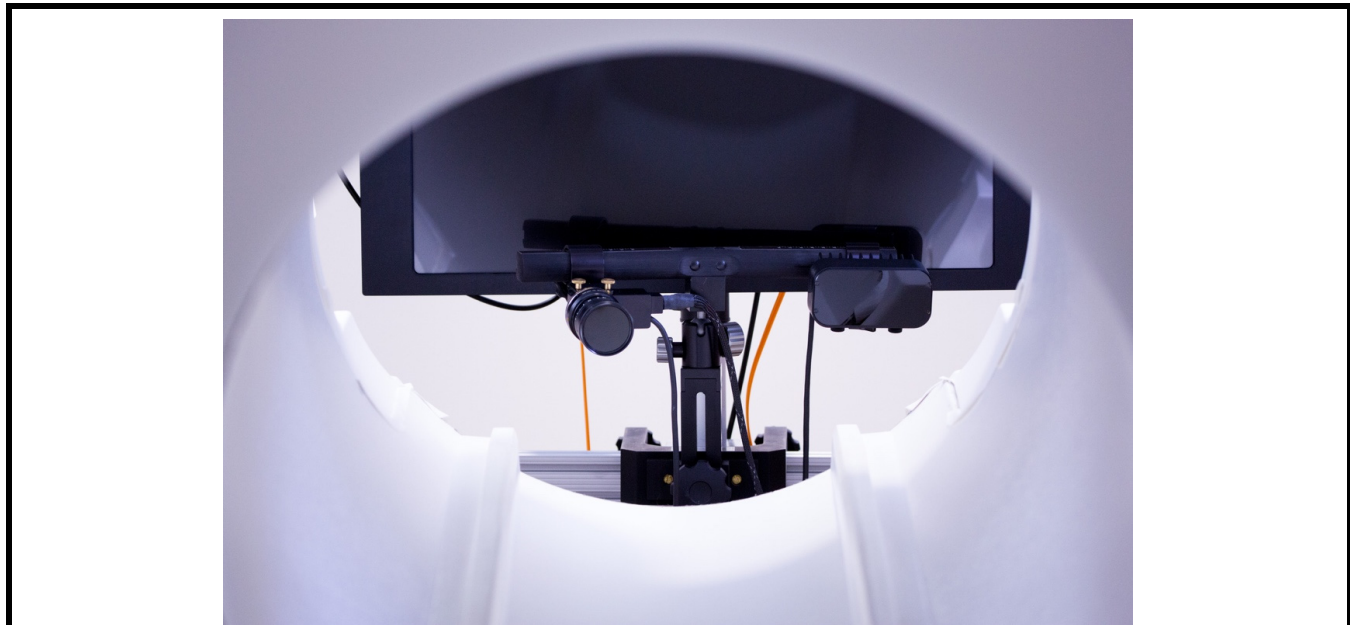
EyeLink 1000 Plus Long-Range Eye Tracker (mounted under the MRI viewing monitor)
